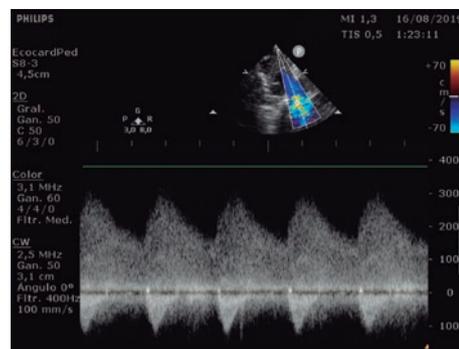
Continuous-wave Doppler echocardiography in the coarctation area with a maximum gradient of 60 mmHg and diastolic prolongation of forward flow.
